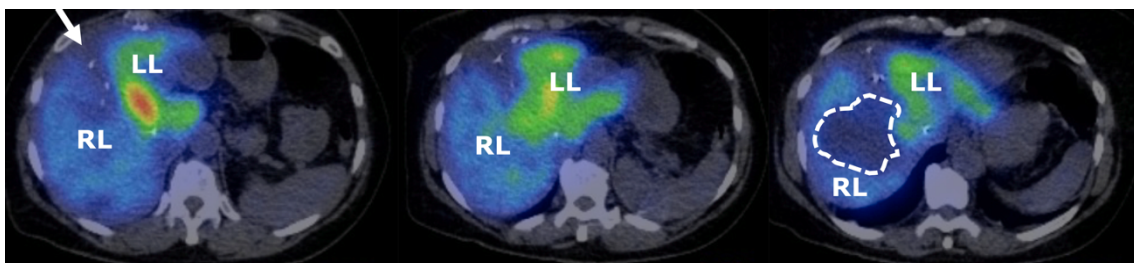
^{99m}Tc -mebrofenin single photon emission computed tomography (SPECT) hepatobiliary scintigraphy on the 10th postoperative day after ALPPS. Inhomogeneity could be observed in the distribution of the tracer between the tumor containing (dashed line) right lobe (RL) and left lobe (LL) of the liver. As the RL was ligated and the liver was transected (arrow)
